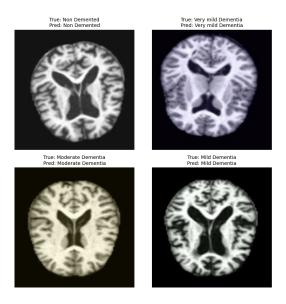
Model predictions on sample MRI scans from each class.
